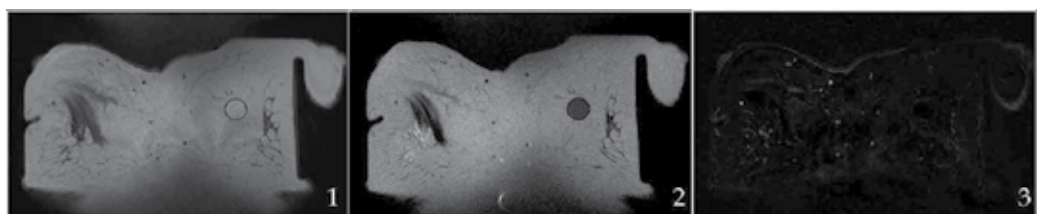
Typical findings for an oil cyst: A nodular cystic lesion with well-defined margins; it is hyperintense on T1-weighted images (1), slightly hypointense on T2-weighted images (2), and does not enhance (3).
